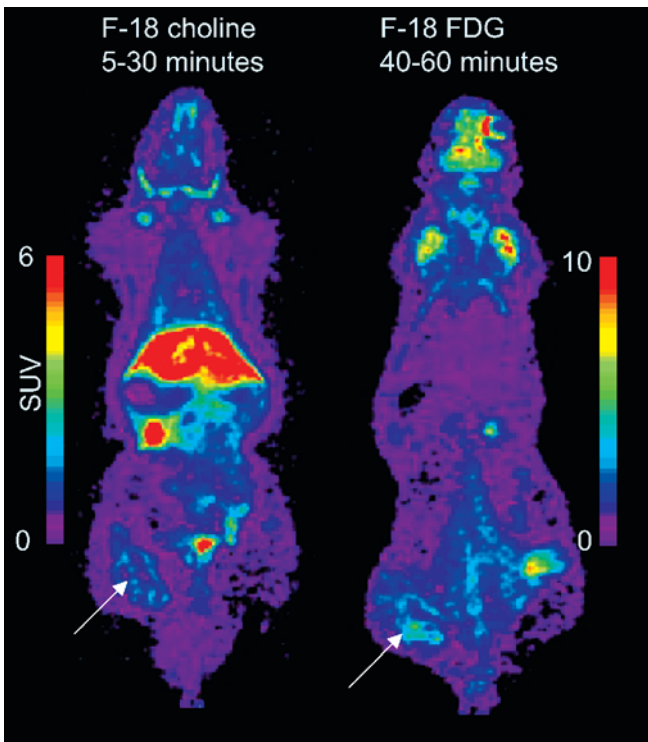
FCH and FDG PET. Shown is a slice with a thickness and pixel size of 0.5 mm. The abscess (arrows) is clearly visualised with FCH (on the left) and FDG (on the right). With FCH the highest uptake is in the liver and kidney
